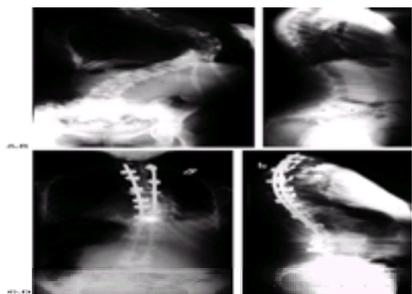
A: This adolescent female presented with a 90-degree right thoracic scoliosis with marked trunk shift to the right. She corrected to 60 degrees on bending to the right. B: Preoperative lateral radiograph. C: Following thoracoscopic release and fusion the patient underwent a posterior spinal instrumentation and fusion, with correction of her deformity. A distraction was used through the concavity of the thoracic curve on the left rod with lumbar compression to restore trunk balance and maintain sagittal alignment through the lumbar spine. D: Postoperative lateral radiograph demonstrates maintenance of appropriate sagittal alignment.
